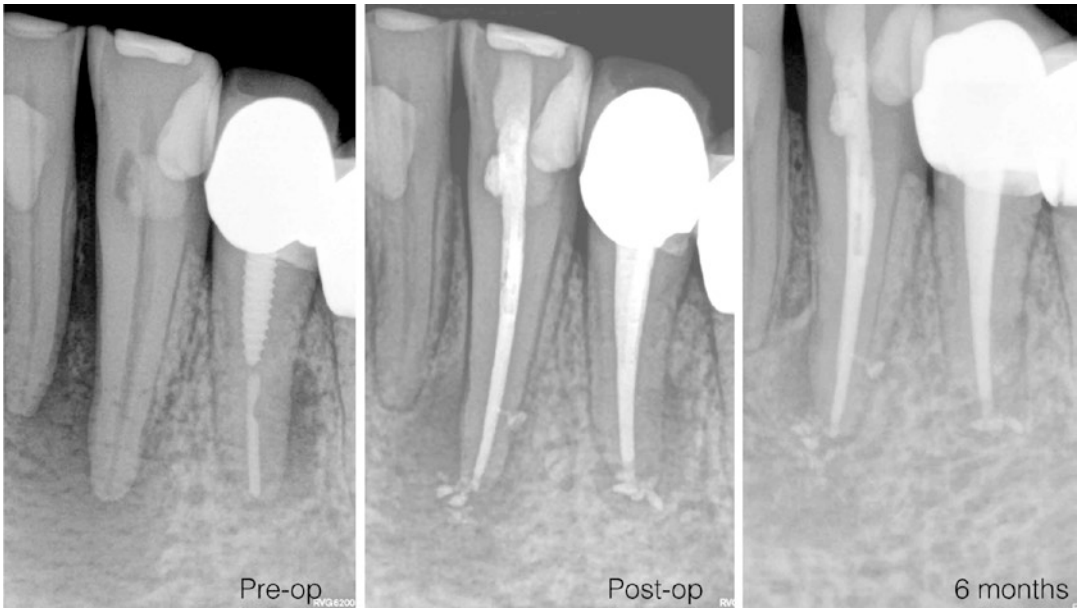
Clinical case showing the radiographic aspect of a root filled with the cold hydraulic condensation technique
